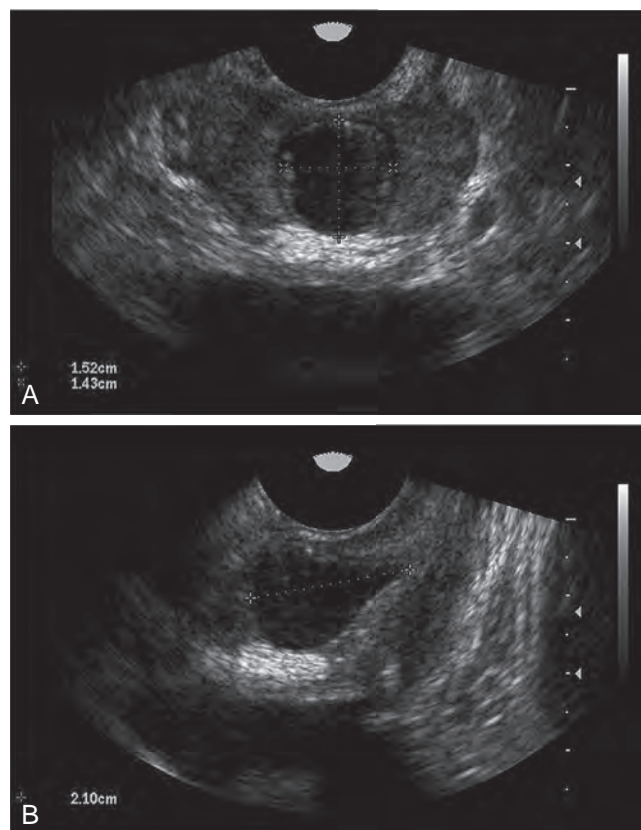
Transrectal ultrasonography revealing an intraprostatic cyst. A is transverse, and B is longitudinal. (Courtesy Marcelo Vieira.)
